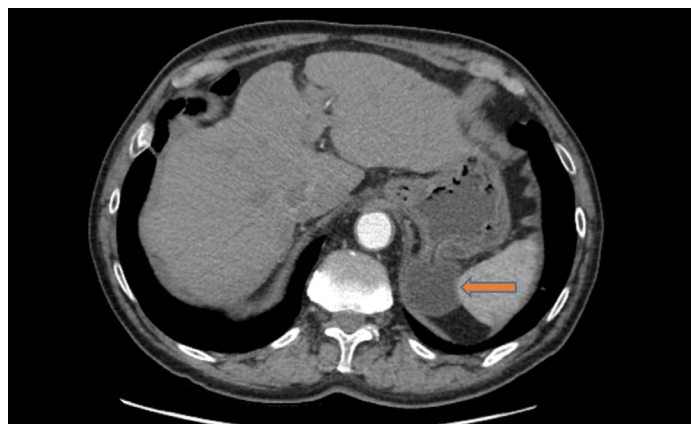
Computed tomography image of gastric fundus diverticulum
